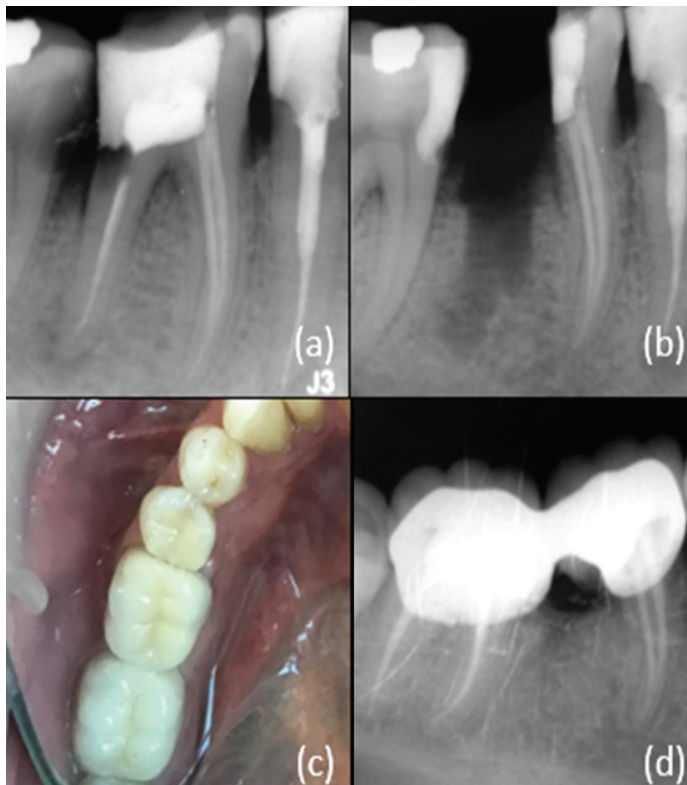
Case 2 (a) Diagnostic radiography of tooth 26 (b) Post-treatment radiography of tooth 26 (c) Metal supported fixed denture applied to tooth 26 (d) 12 months follow-up radiograph of tooth 26
